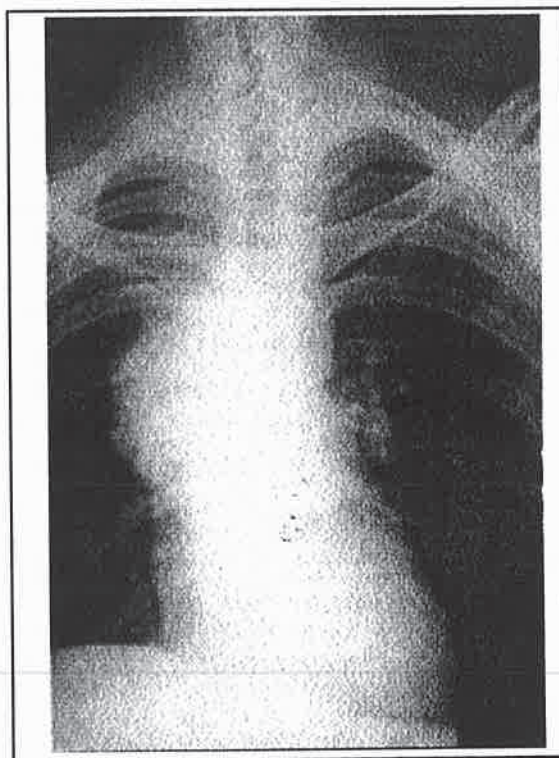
PA X-Ray Image of "Malign Seminoma"
